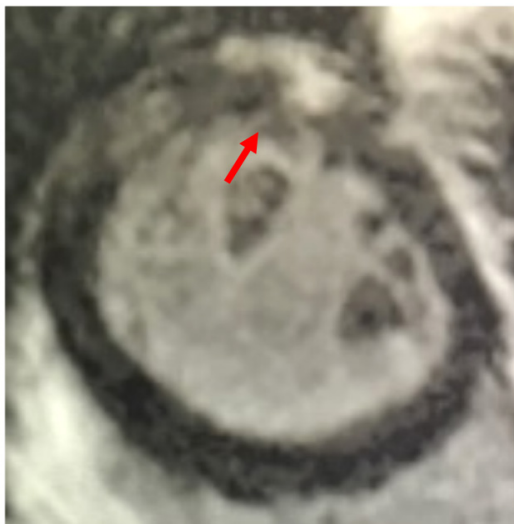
Cardiac MRI (cMRI) at age 41y shows a slightly enlarged left ventricle, mild hypokinesia of the entire myocardium with a left ventricular ejection fraction (EF) of 50%, and focal, transmural late gadolinium enhancement (LGE) of the midventricular lateral wall (arrow).
